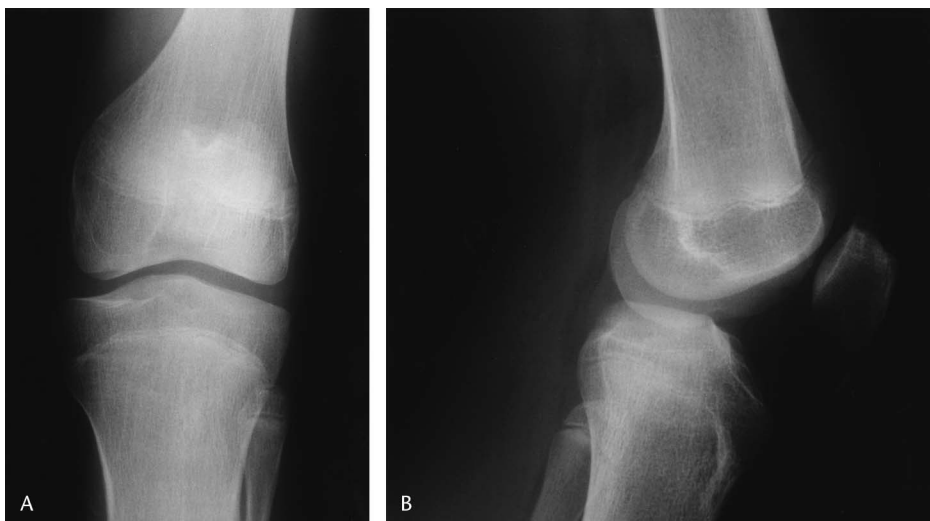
Patient 4. Patient with fibular hemimelia and congenital short femur 1 week prior to single-incision, arthroscopically assisted ACL reconstruction. A, AP radiograph of the knee shows hypoplasia of the lateral femoral condyle, a narrow intercondylar notch, a short fibula, and hypoplasia of the tibial spines. B, Lateral radiograph of the knee shows patella baja and hypoplastic tibial spines.
